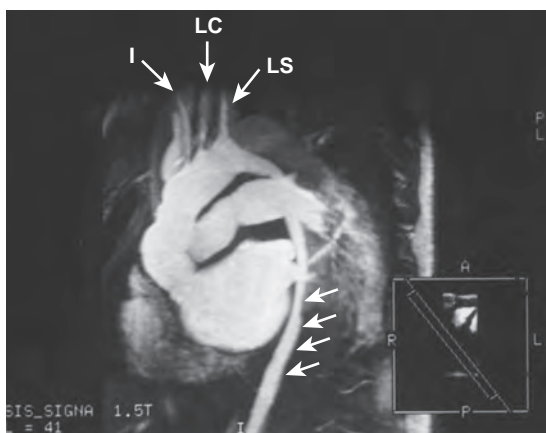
Magnetic resonance imaging of the chest with gadolinium contrast injection in a patient with a type A aortic dissection. The dissection extended into the innominate artery (I), left carotid artery (LC), left subclavian artery (LS), and into the descending aorta (arrows).
